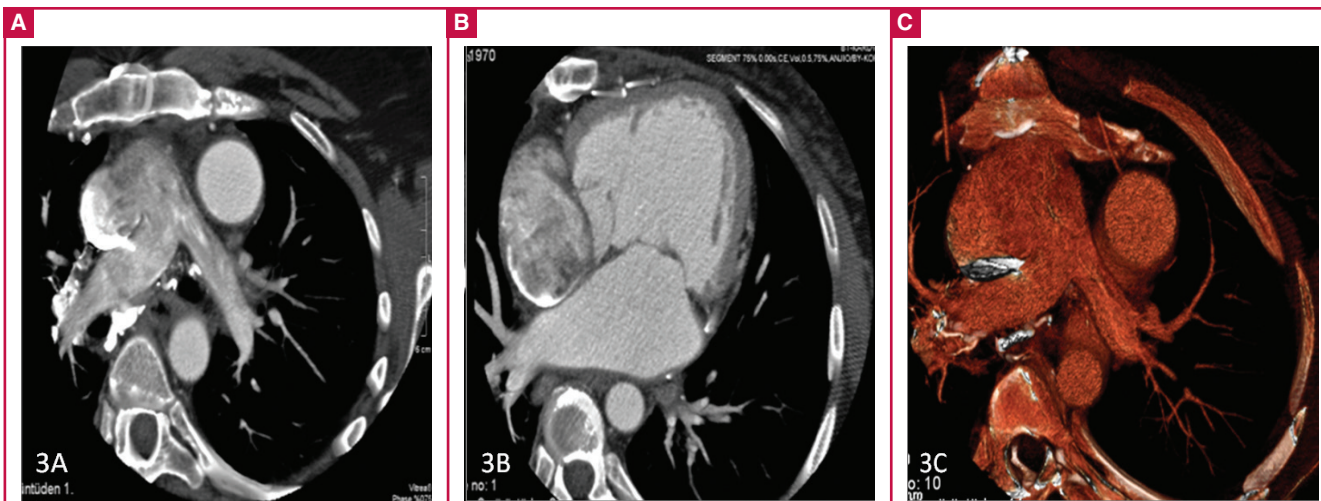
A, B, CT scan showing systemic venous blood entering the pulmonary circulation through a cavopulmonary conduit. C, a hypoplastic right ventricle associated with the left ventricle was seen on CT scan.
